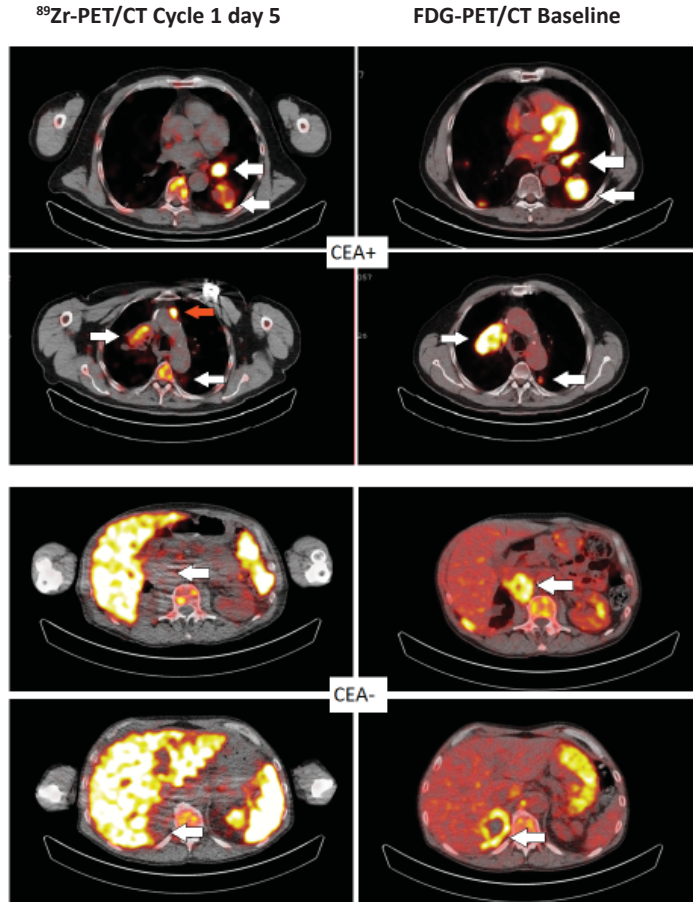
Tumor accumulation in a CEA+ and a CEA- patient treated with 20 mg and 30 mg, respectively. Images of ⁸⁹Zr-PET at cycle 1 day 5 are shown (left) and tumor lesions were identified by ¹⁸F-FDG-PET at screening (right). Accumulation was observed in the left and right hilar lymph nodes, the left dorsal lung lesion (accumulation indicated by white arrows) and a non-pathological lymph node (accumulation indicated by red arrow) in the CEA+ patient (upper panels). For the CEA- patient the adrenal gland and abdominal lymph node lesions were negative on ⁸⁹Zr-PET (lower panels).
